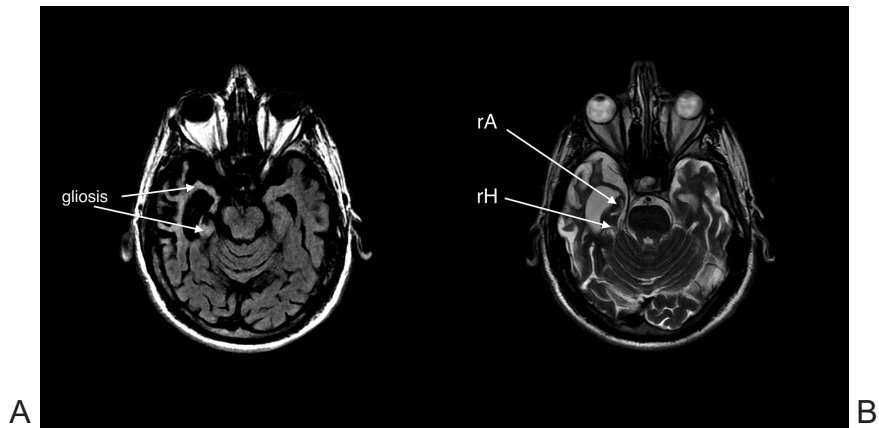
Brain MRI, a. FLAIR T2 sequence, axial plane: hiperintensity of the brain tissue- signs of gliosis (arrow), b. frFSET2 sequence, axial plane: predominant atrophy of the right Hippocampus (rH arrow) and right Amygdala (rA arrow)
